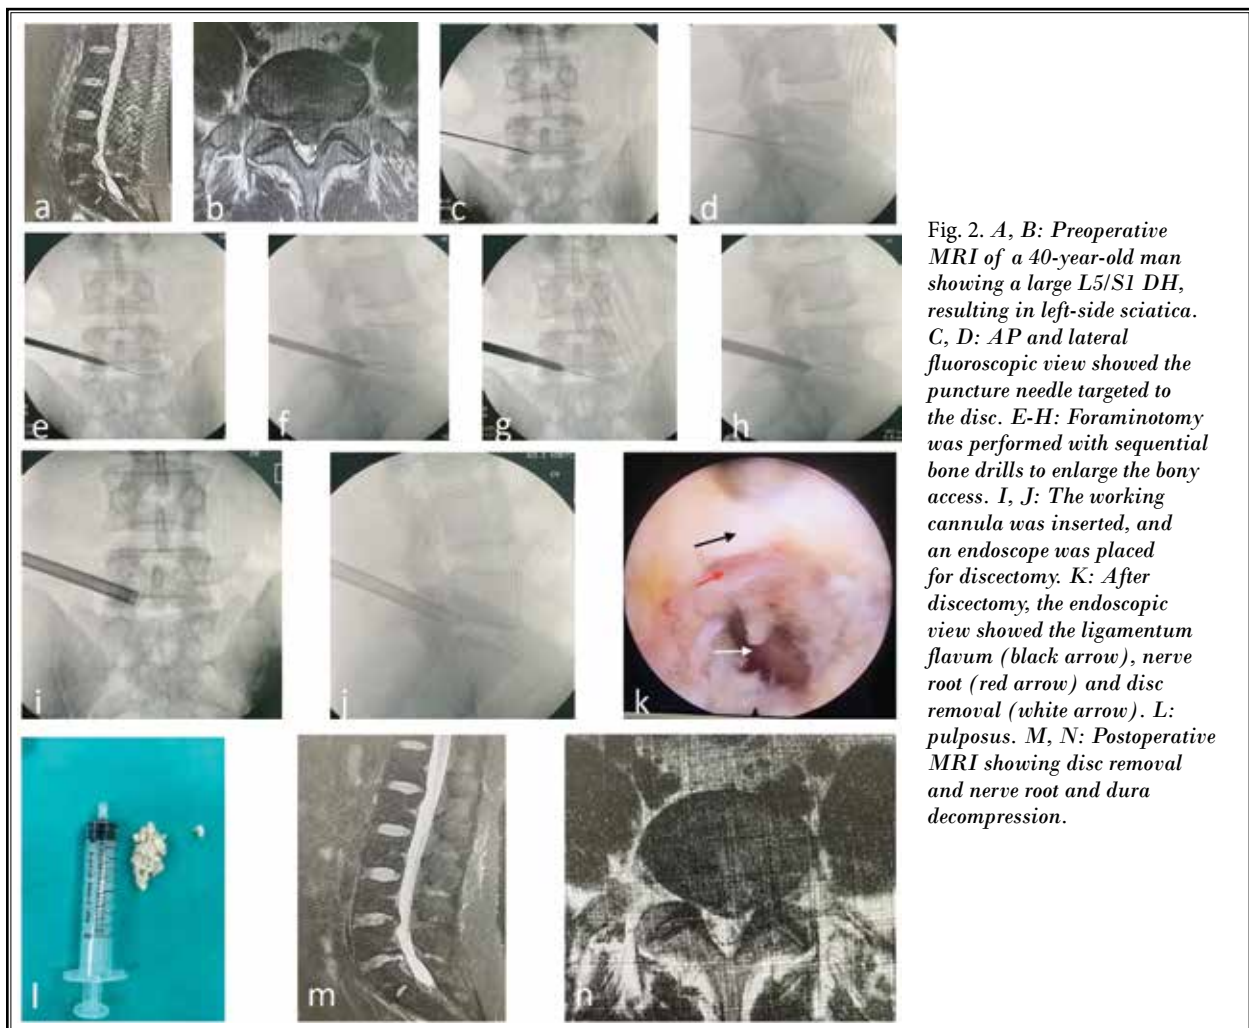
A, B: Preoperative MRI of a 40-year-old man showing a large L5/S1 DH, resulting in left-side sciatica. C, D: AP and lateral fluoroscopic view showed the puncture needle targeted to the disc. E-H: Foraminotomy was performed with sequential bone drills to enlarge the bony access. I, J: The working cannula was inserted, and an endoscope was placed for discectomy. K: After discectomy, the endoscopic view showed the ligamentum flavum (black arrow), nerve root (red arrow) and disc removal (white arrow). L: pulposus. M, N: Postoperative MRI showing disc removal and nerve root and dura decompression.
